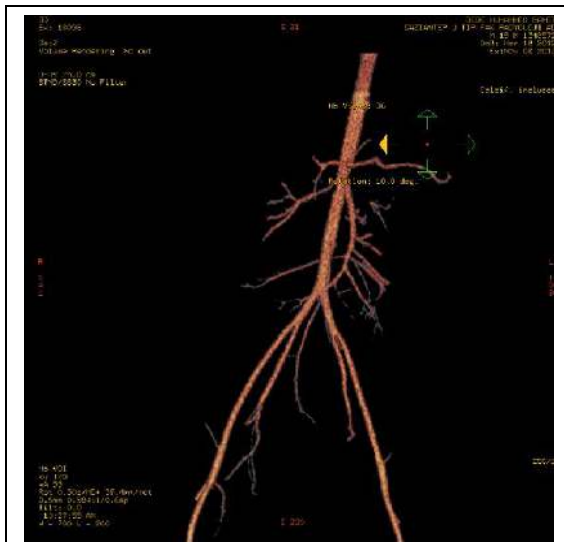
Left renal artery stenosis in computed tomography angiography.
